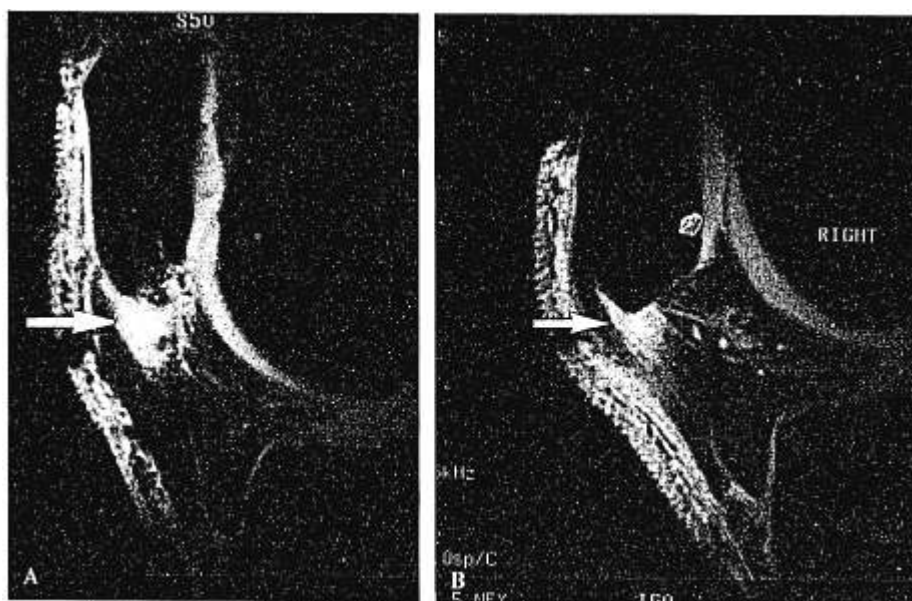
T_2^* -weighted gradient echo images of the patellar tendon from two patients with vastly different clinical outcomes 12 months after surgery. (A) Magnetic resonance image of a 39-year-old man with an excellent clinical outcome. (B) Magnetic resonance image obtained in a 27-year-old man with a poor clinical outcome. Despite the difference in clinical outcomes, both images demonstrate residual marked increased signal of the patellar tendon (arrows).
